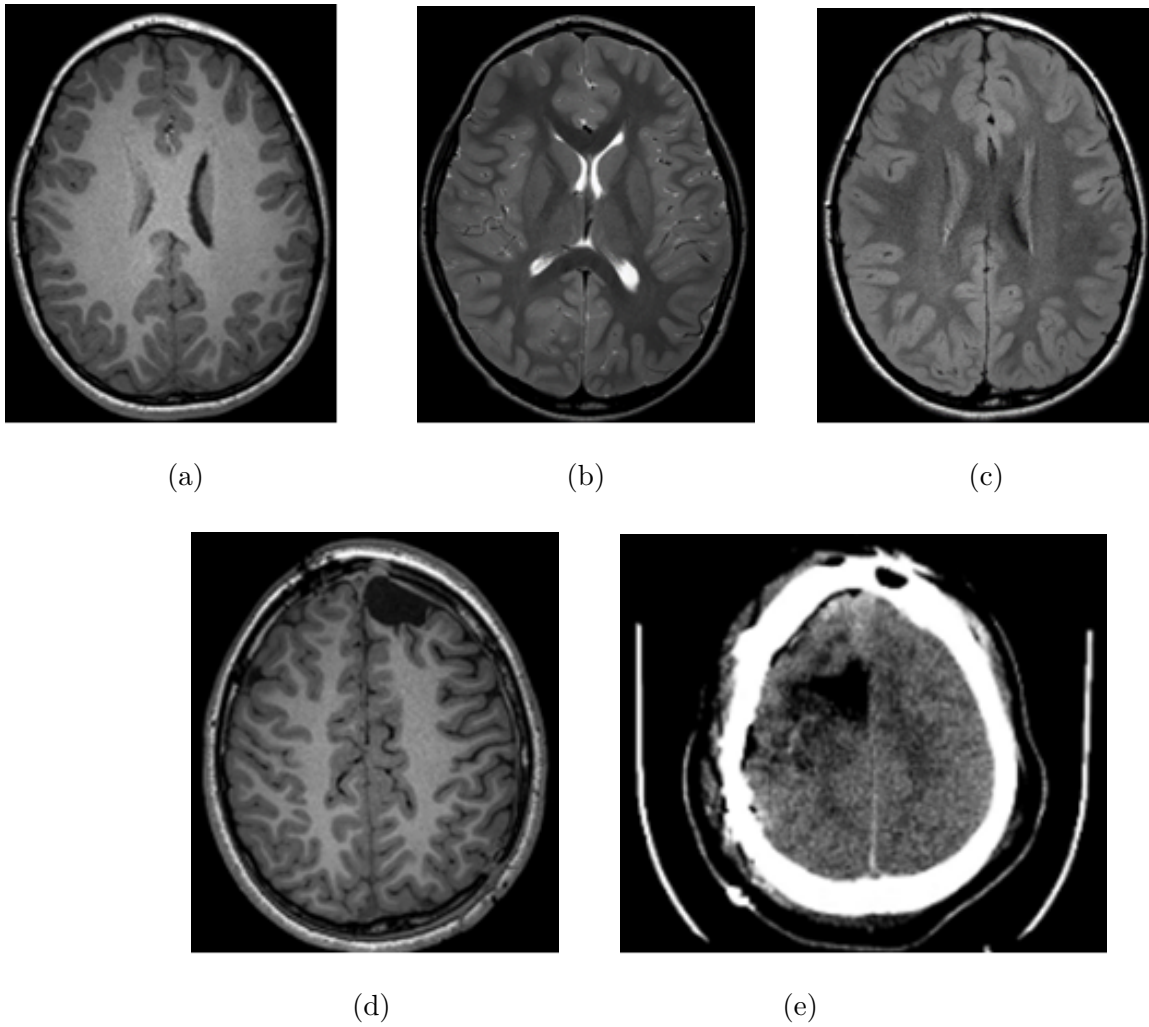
Pre-surgery and post-surgery supplied modalities. Row 1 displays pre-surgery supplied imaging sequences: (a) T1-weighted, (b) T2-weighted, and (c) FLAIR. Row 2 presents post-surgery supplied modalities with resected regions visible: (d) T1-weighted and (e) CT.
